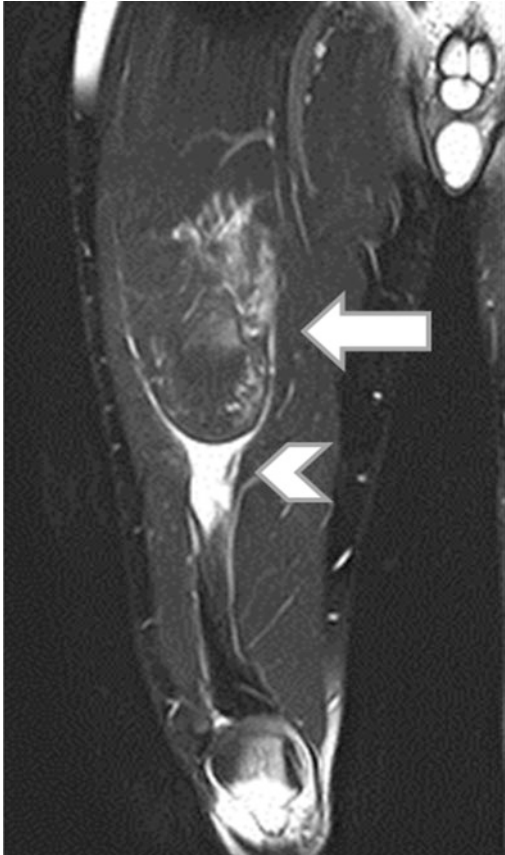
Coronal T2-weighted STIR image in a young football player with severe right leg pain after accidental injury. Image shows diffuse oedema of the quadriceps (*white arrow*) and myotendinous junction complete tear with tendon retraction (*white arrowhead*)
